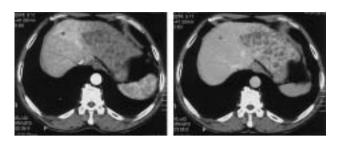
Abdominal computed tomography with intravenous contrast performed upon admission to the university hospital. The tumor in the left liver lobe was low density without enhancement in the early phase (A). Subsequently, the tumor showed gradual enhancement in the late phase (B).
